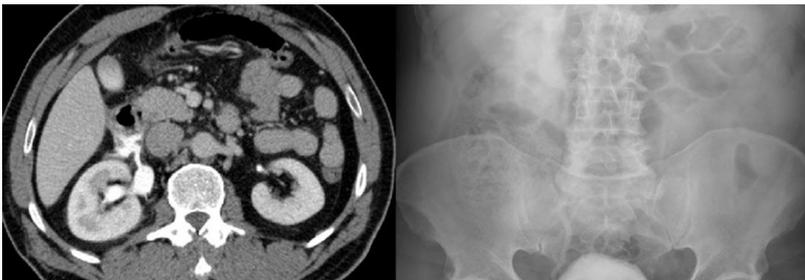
Contrast Extravasation in CT and KUBG
